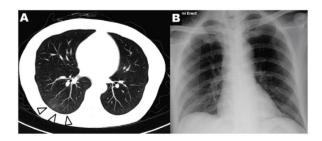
Ground glass opacities seen on computed tomography in a patient with COVID-19 (Image A) but not visible on CXR (Image B).
